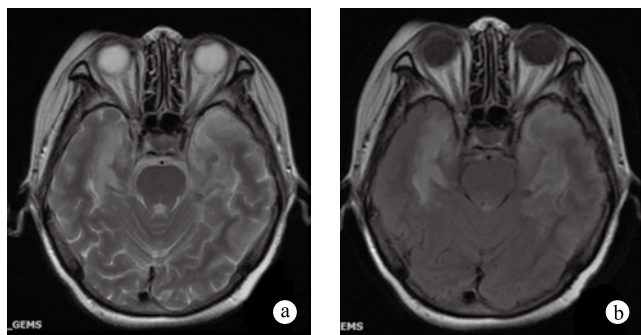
MRI scan: There was no widening and deepening in the brain pool and the cerebral sulcus, and no displacement of the midline structure and no abnormal signals in the cerebellum and brainstem were found
